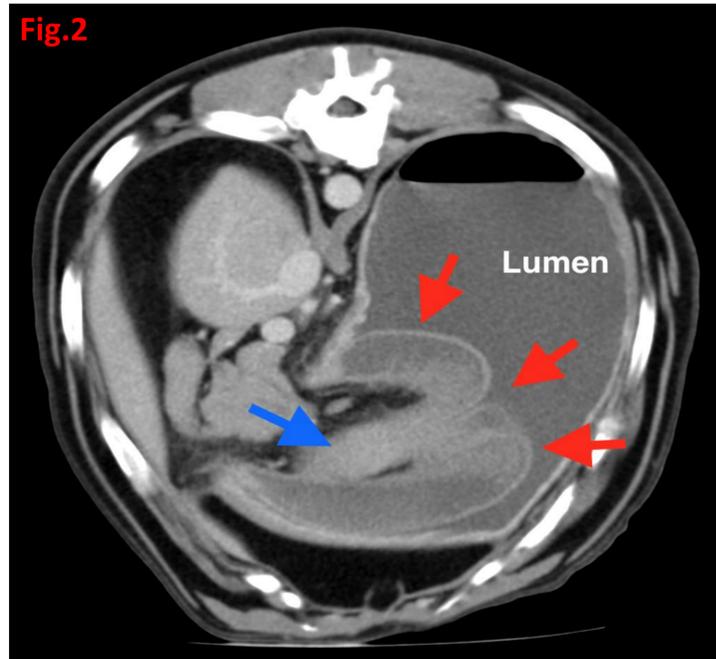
CT image in venous contrast phase, showing a transverse oblique reconstruction optimised for demonstrating the pylorogastric intussusception. The inverted walls of the intussusceptum (red arrows) are markedly thickened and project into the stomach lumen. Although contrast enhancement is present, the thickened walls have a layered appearance, suggestive of wall oedema. The duodenum (blue arrow) is also thickened.
